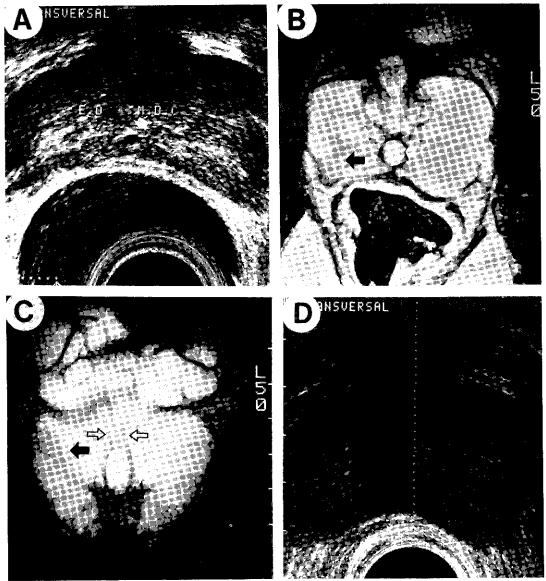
Müllerian duct cyst (M.D.C). and prostatic atrophy. A.4mm-sized, round, hypoechoic cyst (white arrow) is seen at the midline of prostate and right ejaculatory duct (E.D., empty arrow) is also seen. B (axial T 2WI), C (coronal T2WI). Centrally located cyst is as with high signal intensity on T2-weighted view, and showing as a typical tear-drop shaped cyst (white arrow). Both sides of seminal vesicles show markedly dilated. Ejaculatory ducts are faintly but clearly visualized (empty arrow). Focal prostatic atrophy is seen as low intensity area (bold arrow). D. Post-TUR ultrasonography. Cyst and ejaculatory ducts are not seen, and patient no longer complaned of hemospermia.
